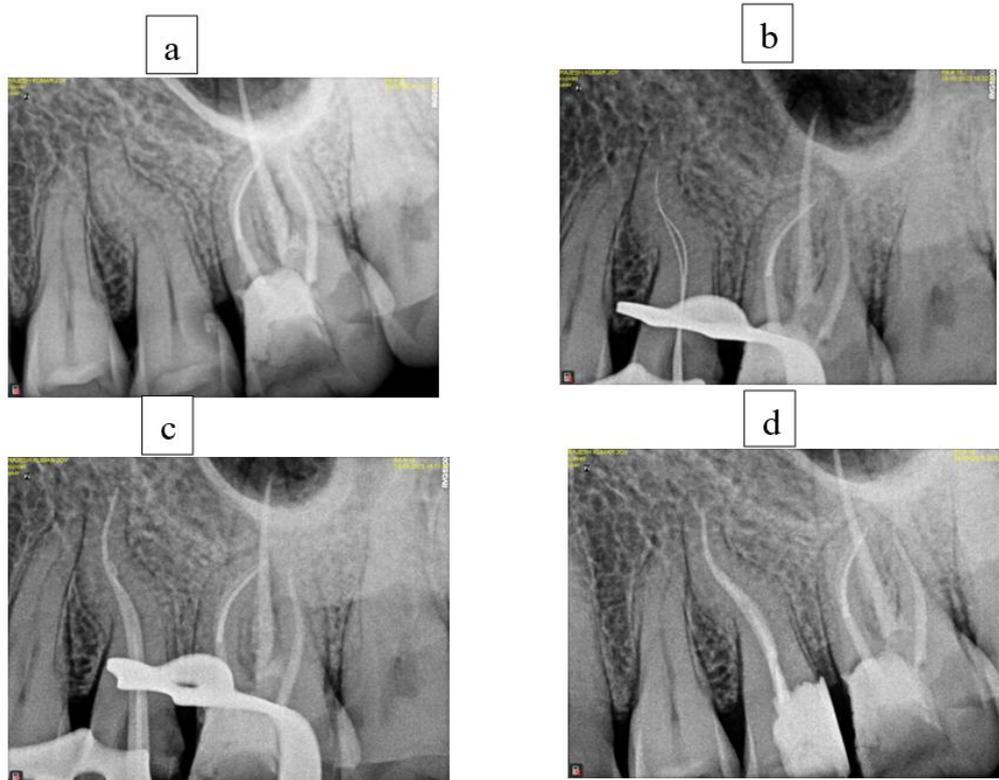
a) Pre-operative IOPA x-ray b) working length IOPA x-ray c) Master cone IOPA x-ray d) Post-operative IOPA x-ray
